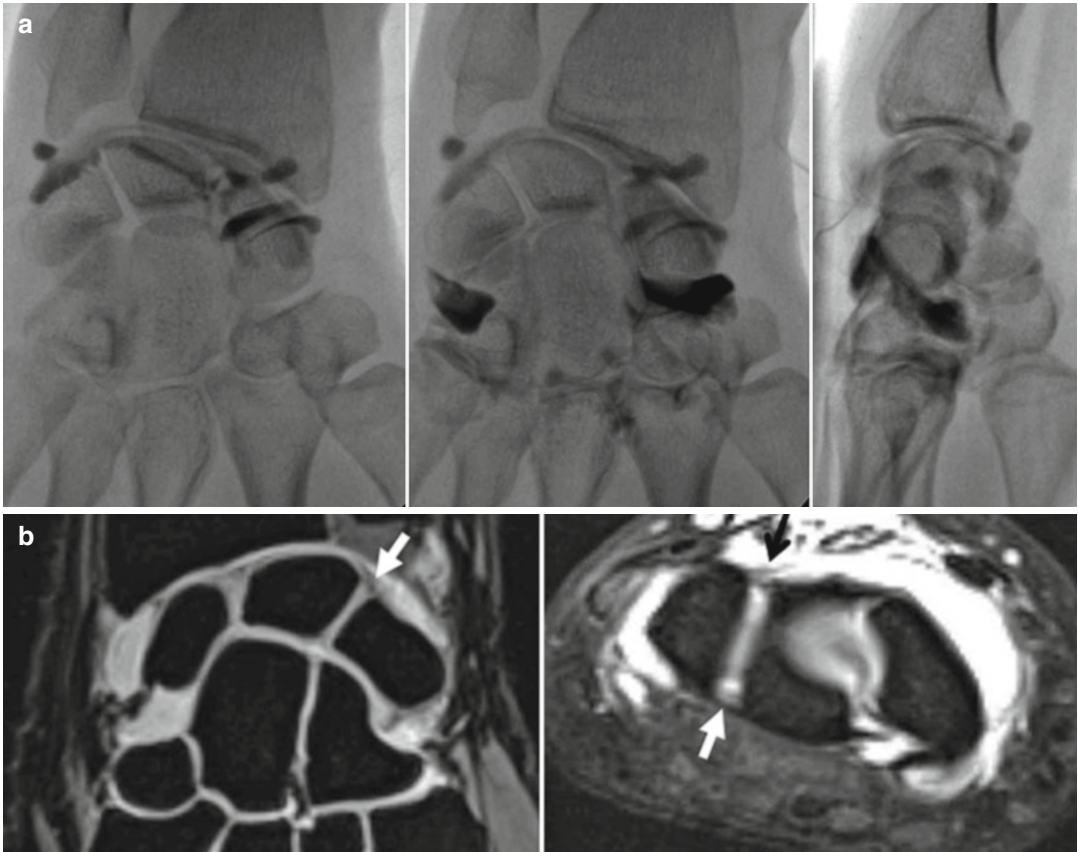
(a) Arthrography of the normal wrist, after injection into the radiocarpal compartment; the contrast medium does not enter the midcarpal compartment. The midcarpal compartment was filled with a second injection of 3 ml contrast medium solution (*middle and right images*). (b) coronal and axial MR images: on coronal
